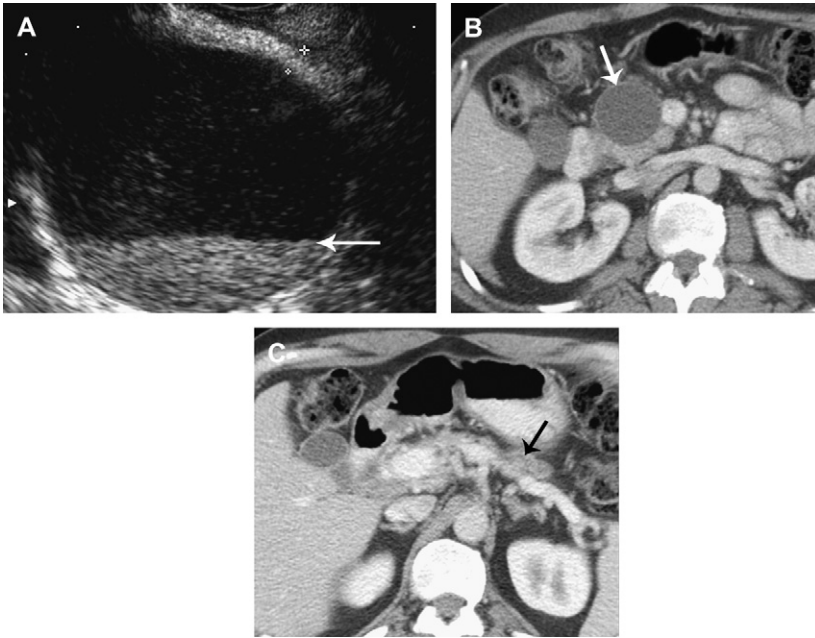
Fifty-six-year-old man who has a pancreatic pseudocyst. (A) Endoscopic ultrasound image shows a spherical mass with a thin but measurable wall (*between cursors*) and a fluid-debris level (*arrow*) in its dependent portion. (B) A CT scan performed 2 months later shows decrease in size of the pseudocyst (*arrow*), a thin wall, and near-water-attenuation contents. (C) The body-tail segment of the pancreas (*arrow*) is atrophic and the pancreatic duct is dilated, indicating chronic pancreatitis.
